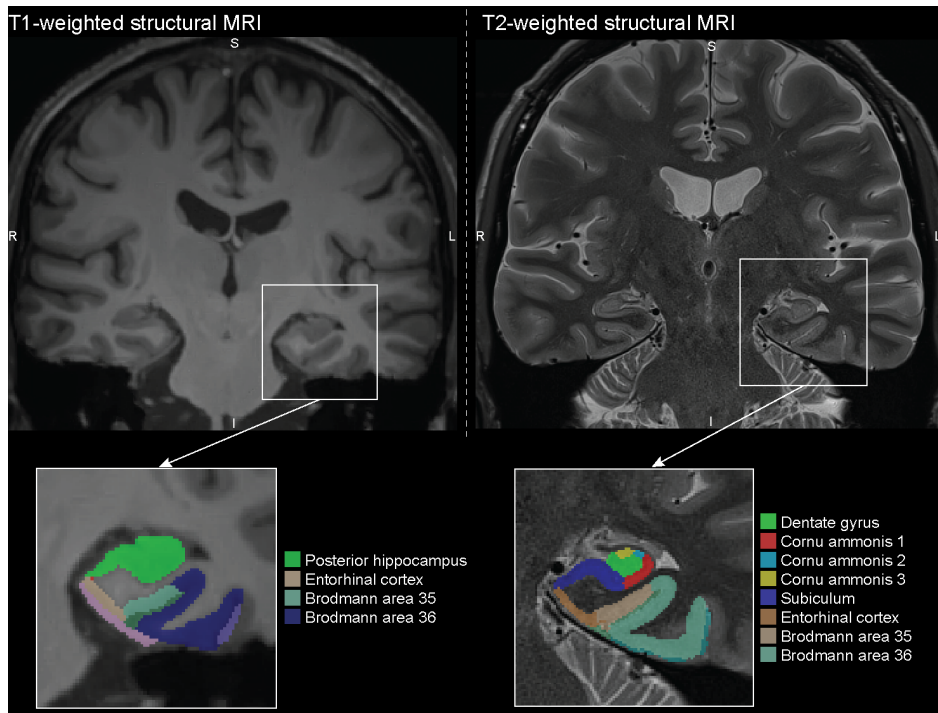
Coronal T1- and T2-weighted structural MRI scans.
